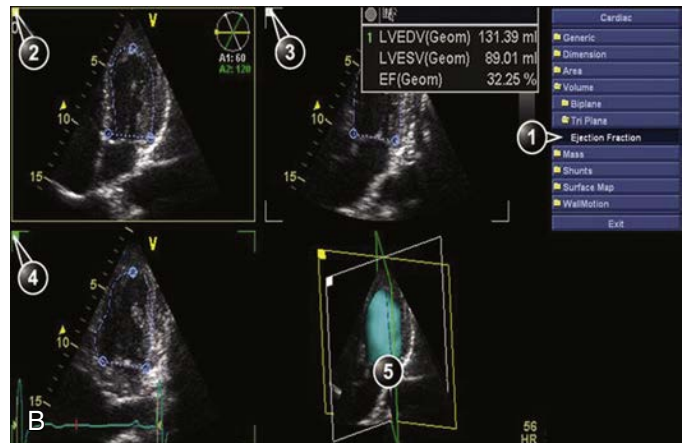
Three-dimensional model of left ventricular (LV) function. (A) Automated determination of LV ejection fraction (LVEF) using volumetric assessment and multislice (5 to 12) short-axis volumes. (B) Three-dimensional full volume of the left ventricle can be processed from apical four-chamber, two-chamber, and long-axis views with special analytical software to create a dynamic three-dimensional cast.
